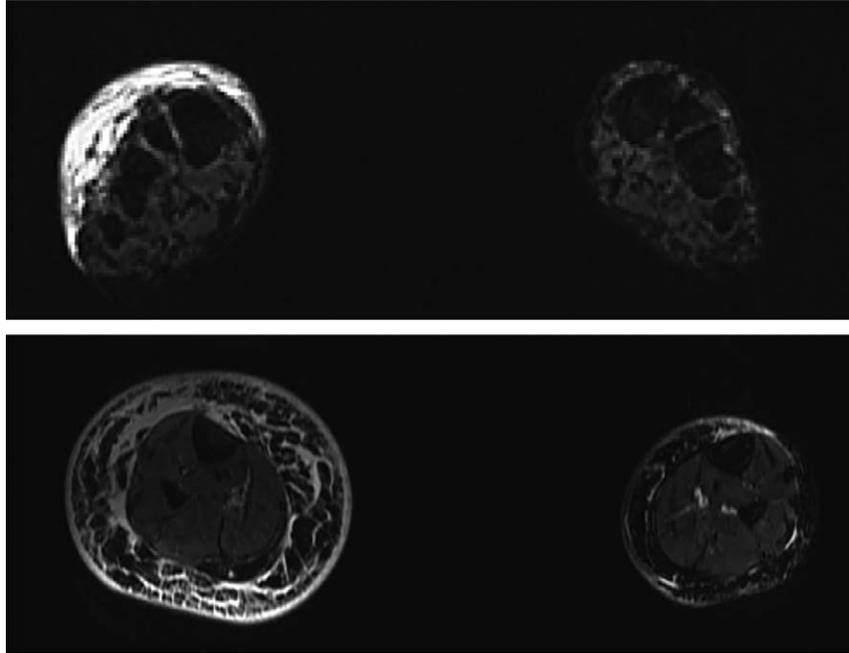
Representative magnetic resonance images from an assessment of right lower extremity lymphedema, performed at 3.0 T. Axial fluid-sensitive, fat-suppressed, short-tau inversion recovery images at the midfoot (*above*) and midcalf (*below*) demonstrate marked edema of the right leg in comparison with the left, denoted by areas of high signal intensity, with marked thickening of the subcutaneous soft tissues. The muscles are spared. (Images courtesy of Dr. Leo Tsai, Body Imaging Radiology, Beth Israel Deaconess Medical Center, Boston, Mass.)
